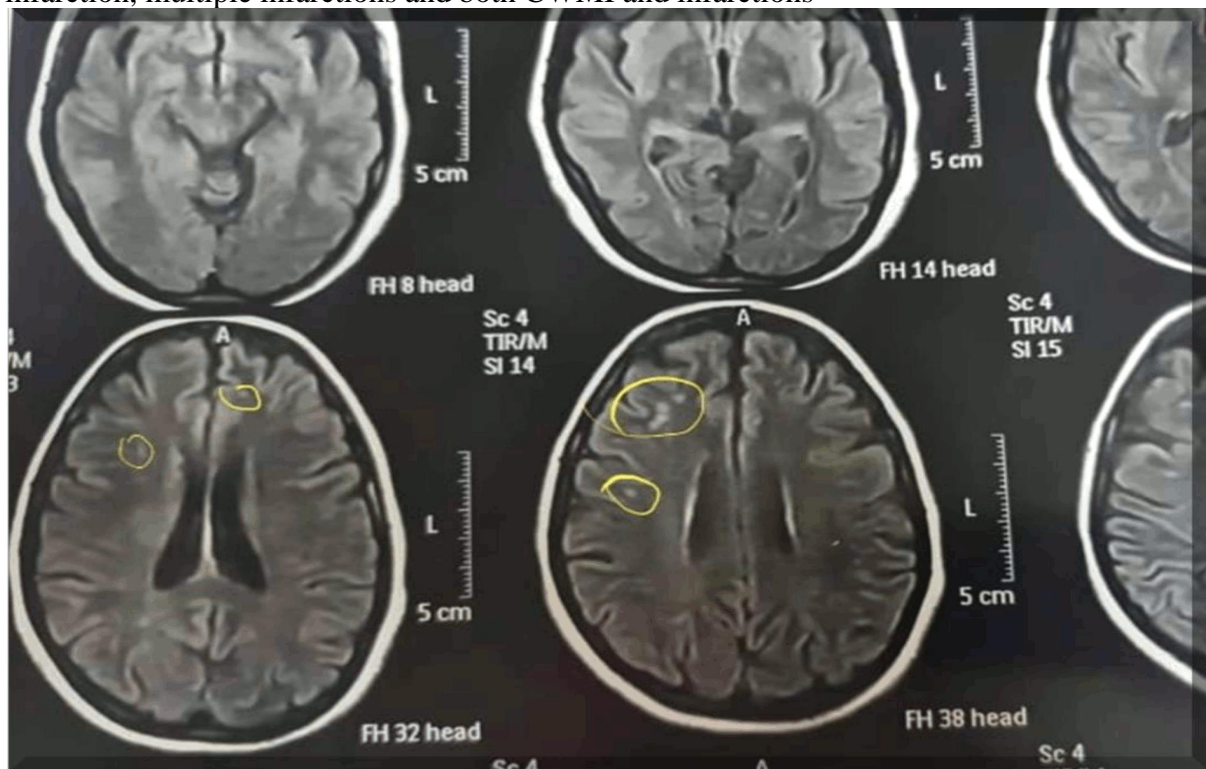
MRI of 51 and 49 years old patients presented by NSTEMI (red arrows highlights different sized infarctions)
